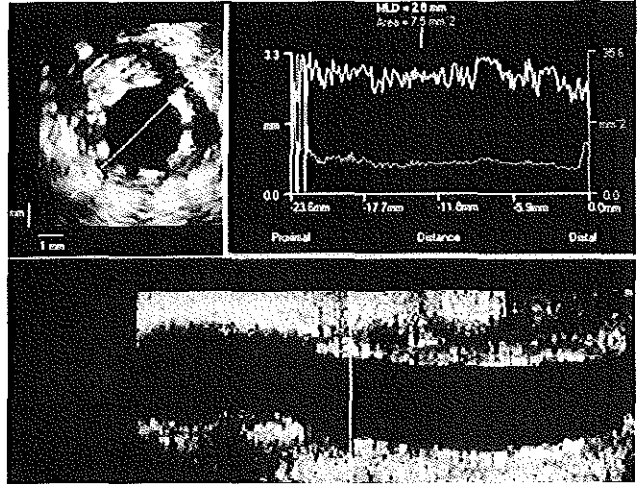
Three-dimensional intravascular ultrasound analysis of a well-expanded Palmaz-Schatz stent in a coronary segment with an eccentric atherosclerotic plaque. A 3-dimensional analysis system (EchoQuant) was used to acquire the intravascular ultrasound images automatically. A longitudinally reconstructed view (lower panel) was obtained that could be rotated around the long axis of the vessel segment. Automated image segmentation was performed by a pattern-recognition algorithm (Acoustic Quantification), which identified the blood pool inside the lumen. The luminal contours were rapidly checked and, if necessary, manual corrections were made on individual ultrasonic images. A display of the lumen area and corresponding diameter measurements facilitated on-line assessment and quantification of the luminal dimensions (right upper panel). MLD=minimal luminal diameter.
